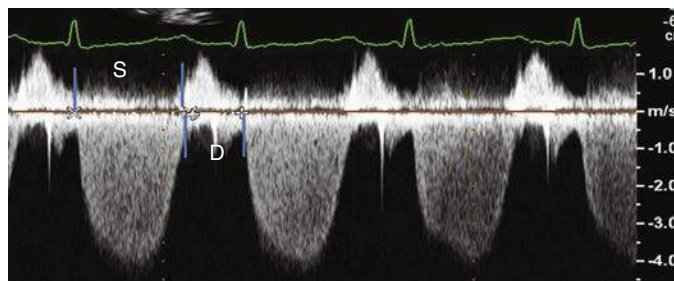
Continuous wave Doppler of the tricuspid valve regurgitation from patient with pulmonary artery hypertension. D, Effective RV diastolic duration; S, effective RV systolic duration.
